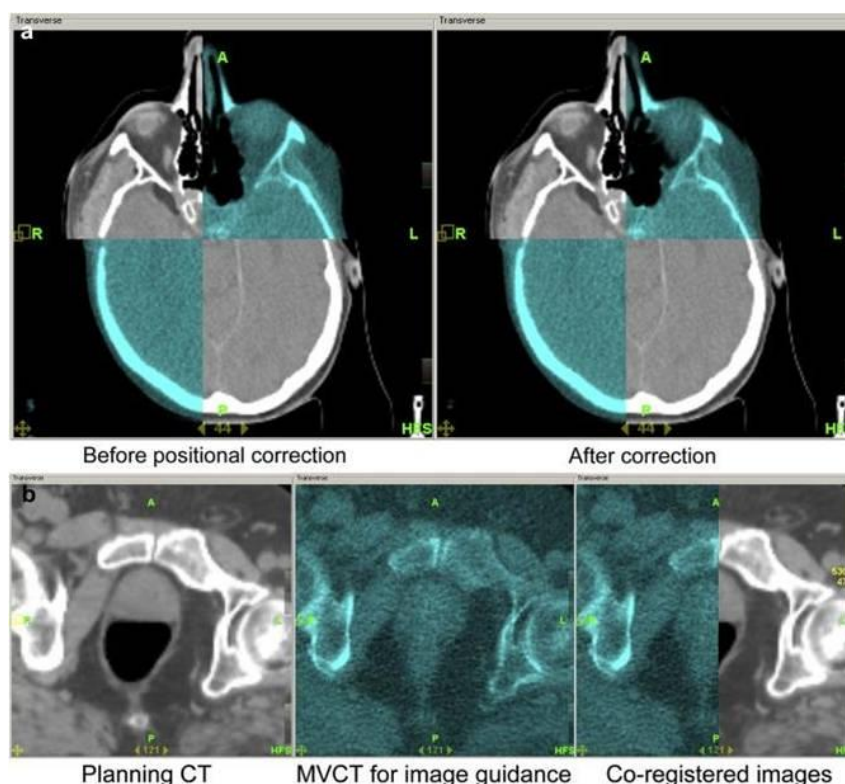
Use of MVCT images (shown in blue) to apply setup corrections based on the registration with the planning CT (grey).
